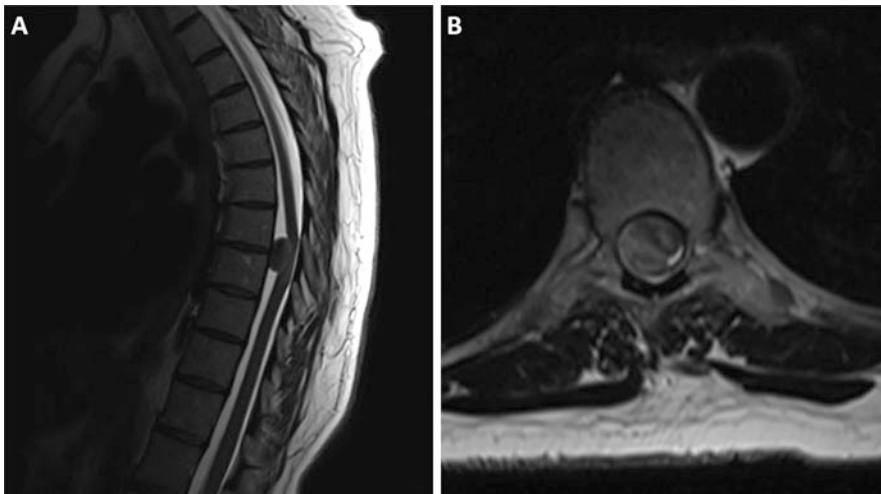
A 51-year-old WF presented to the emergency department with a 2-month history of progressive BLE weakness. MR imaging (a and b) demonstrated a large
